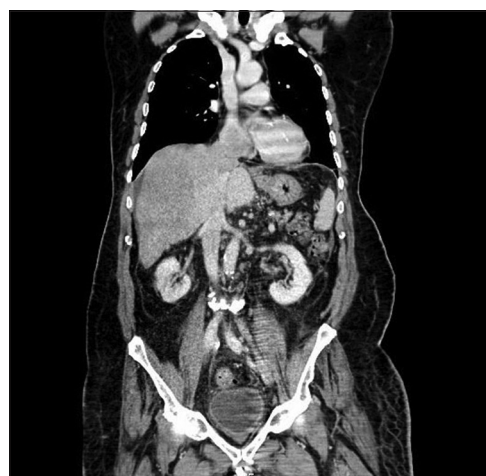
This is a coronal plane of Computed tomography scan abdomen that showed hepatoma at segments 6 and 7 invading the right hepatic vein as well as confluence of the inferior vena cava extending into the right atrium of the heart with small ascites with no splenomegaly or other metastasis
